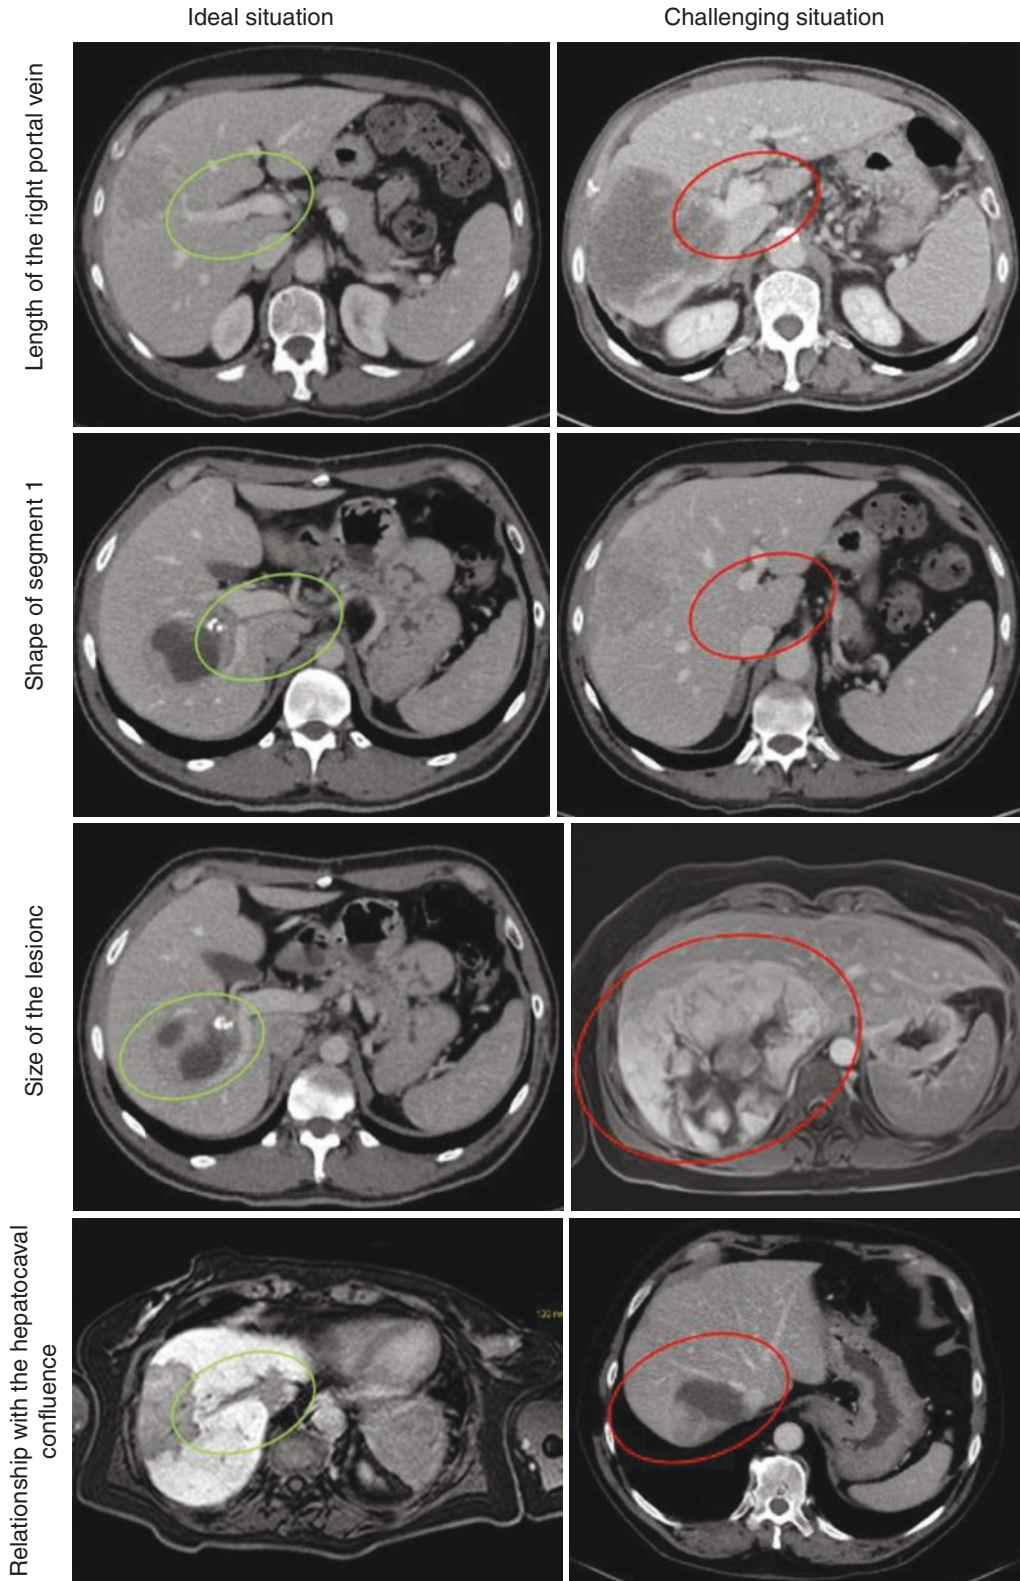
Preoperative characteristics of liver anatomy and disease to be evaluated at preoperative CT scan to grade the difficulty of minimally invasive right hepatectomy
